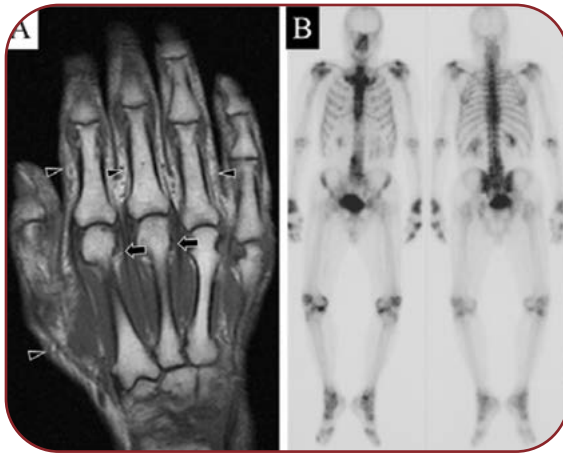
(A) Coronal T1-weighted magnetic resonance imaging at the time of presentation showing soft tissue edema (arrow heads) and thickening of metacarpophalangeal (MCP) joints (arrows) without erosive lesions; (B) Gallium scintigraphy showing almost symmetrical accumulation in wrist joints, MCP joints, knee joints, and ankle joints
